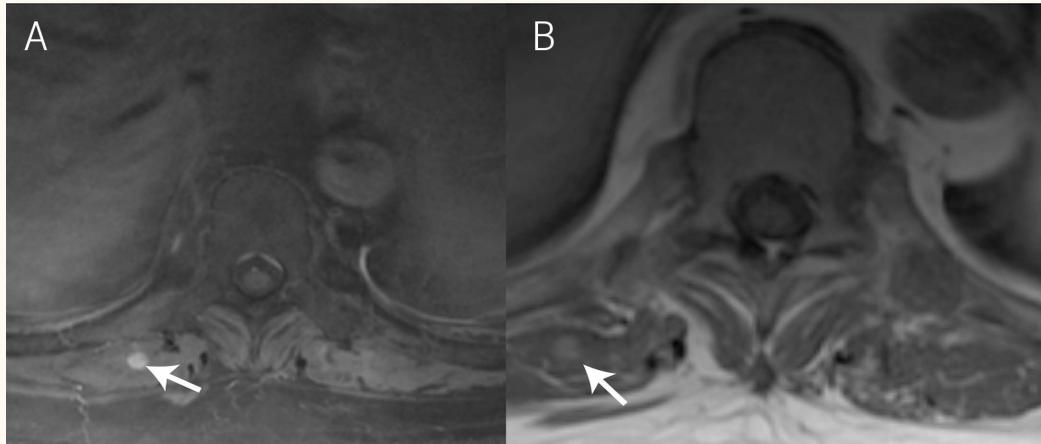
Magnetic resonance imaging (MRI) of a 49-year-old man with renal cell carcinoma. A: Post-contrast fat-saturated T1-weighted axial MRI scan at the L2 level showing a small metastasis in the right paraspinal musculature that is enhanced brightly. B: Pre-contrast T1-weighted axial MRI scan at the same level shows that this small metastasis is hyperintense to the surrounding muscle (arrow).
